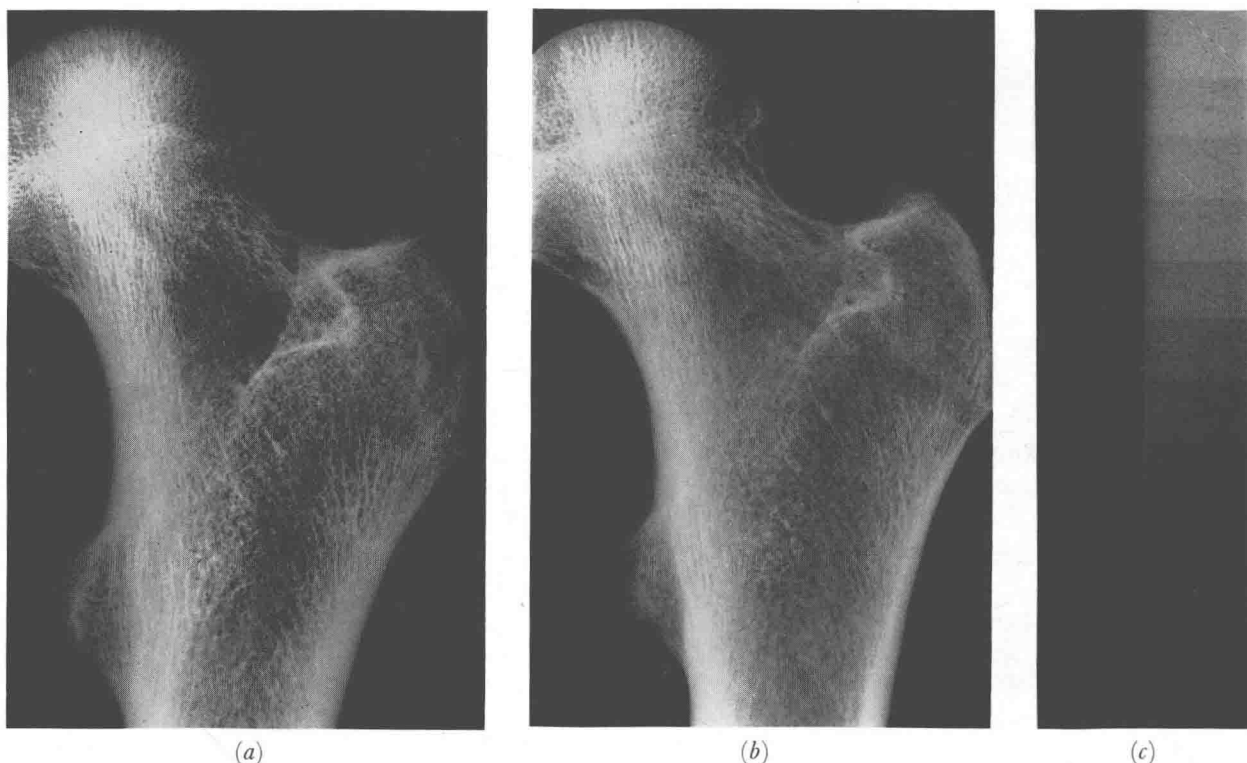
Radiographs demonstrating effect of variations in kilovoltage on contrast. (a) The upper end of a femur using 45 kV. (b) The same bone using 90 kV. The degree of contrast between the various parts of the bone is less clearly shown. The hole through the head and greater trochanter (through which a wire passed to join it to the rest of the skeleton) is much more clearly visible. Air is always well shown in the body in radiographs made with a high kilovoltage. (c) Radiographs (here joined together) of an aluminium step wedge. On the right the gradations of density are easily distinguished at 45 kV. On the left, at 90 kV, the contrast between the various densities is almost eliminated
